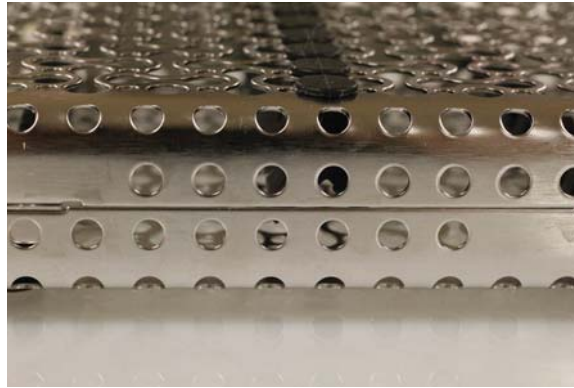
Dental scalers and periodontal probes with dried organic debris in an Infinity Series cassette before ultrasonic cleaning.
